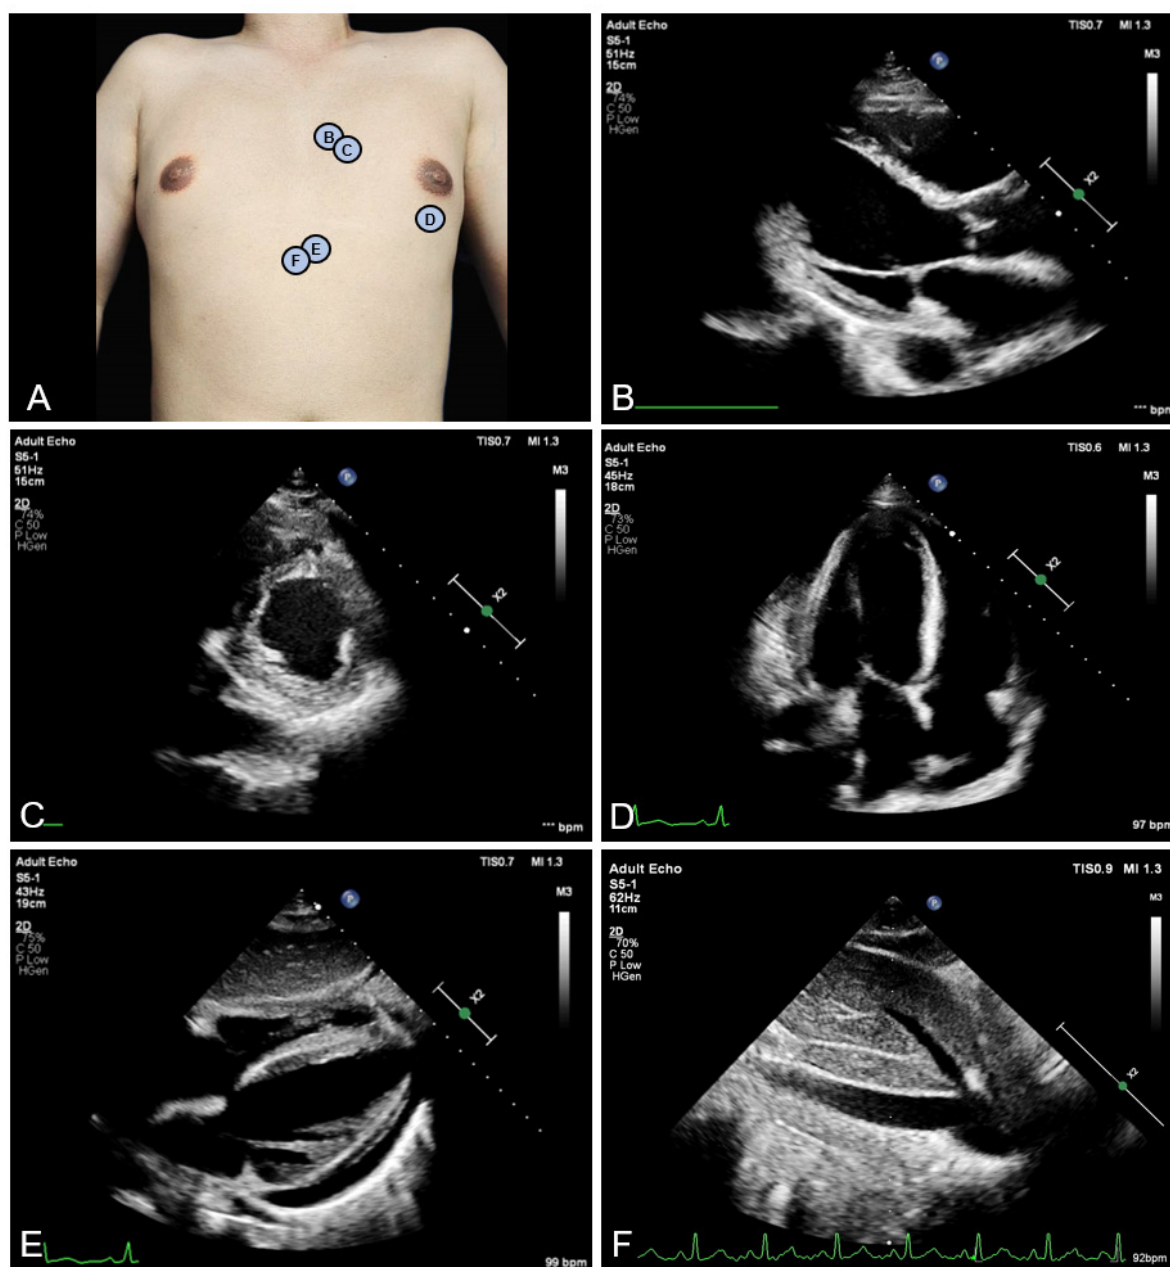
Standard views of transthoracic echocardiography. 1A: Anatomical landmark of chest wall for probe positioning; 1B: Parasternal long axis view; 1C: Parasternal short axis view; 1D: Apical 4-chamber view; 1E: Subcostal view; 1F: Inferior vena cava longitudinal view.
